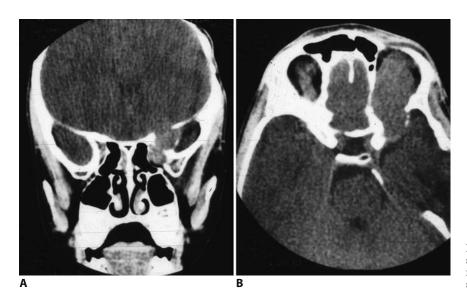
(A) Coronal and (B) axial CT scans showing the extension of recurrent fibrosarcoma into the brain and paranasal sinuses.
